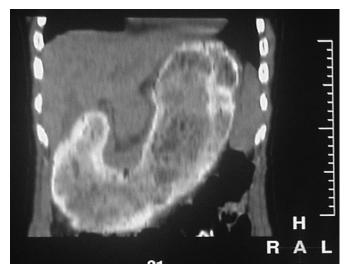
Preoperative CT scan image, coronar aspect
